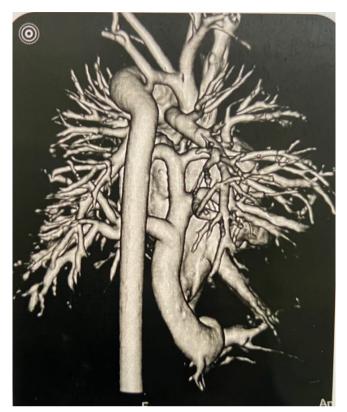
Angio-CT of the heart of a newborn with the collector described in prenatal examination reports
